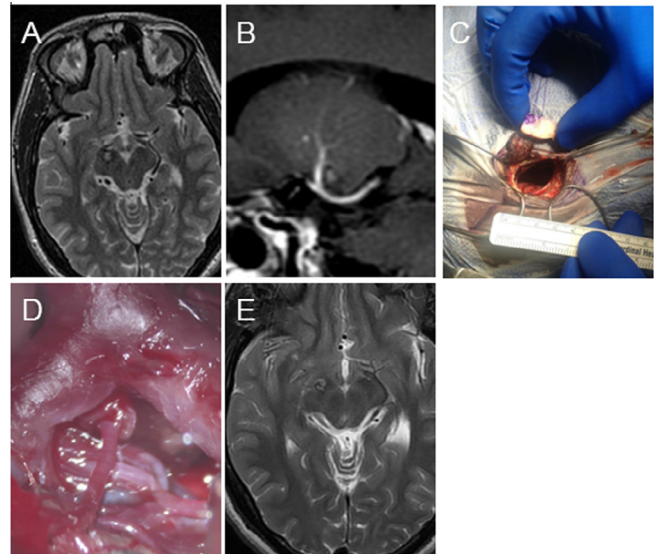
Patient 1: Eyebrow approach. Preoperative axial T2-weighted (A) and sagittal post-gadolinium T1-weighted (B) MRI demonstrates a cavernous malformation in the right cerebral peduncle presenting to the surface anteriorly. Eyebrow craniotomy (C). Given the height of the lesion, the best corridor is through the supracarotid triangle (D). Follow-up T2-weighted axial MRI demonstrates complete resection (E). (This figure is available in colour at <http://www.sciencedirect.com/>).
